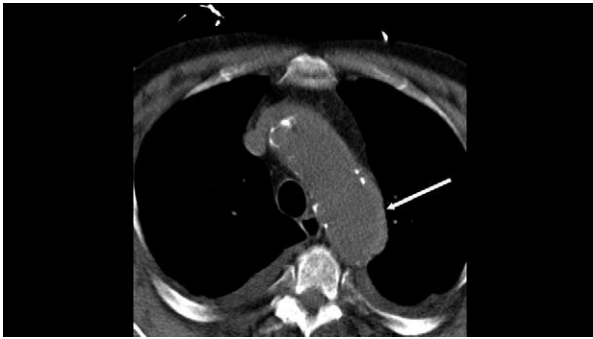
Attenuation of aortic wall visualized with a noncontrasted computed tomographic scan suggesting acute intramural hematoma.
